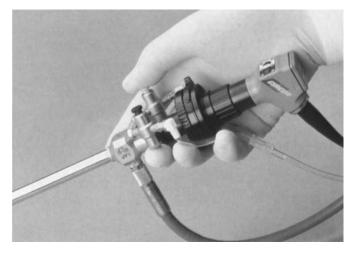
Hydrolaparoscope (Circon/ACMI, Stamford, CT).
